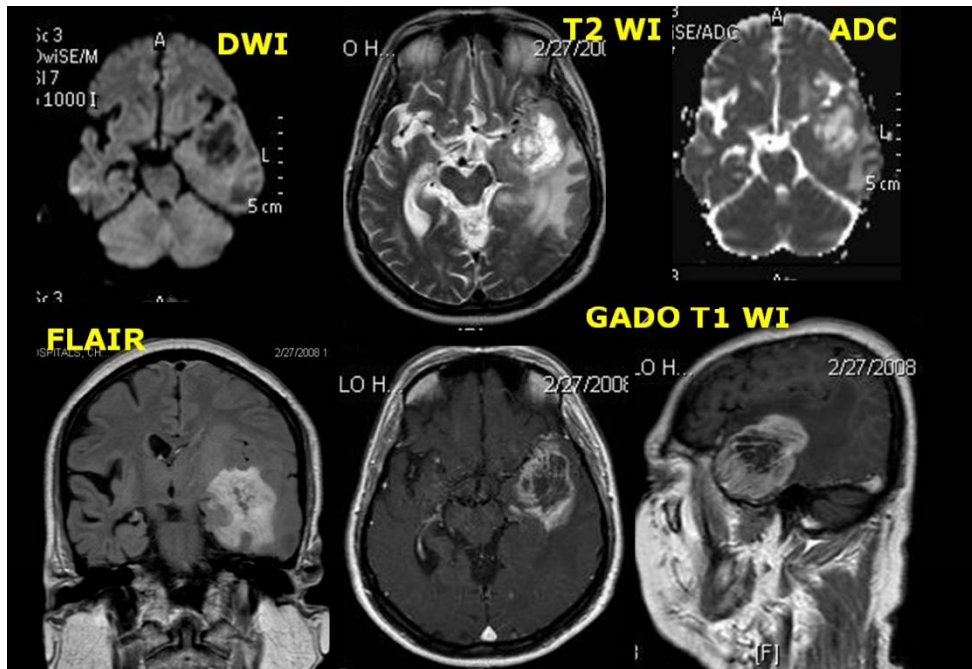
Fig No: 7 A. MRI shows, a large, thick nodular, peripheral enhancing necrotic lesion with edema and mass effect in the left temporal lobe representing high grade neoplasm
